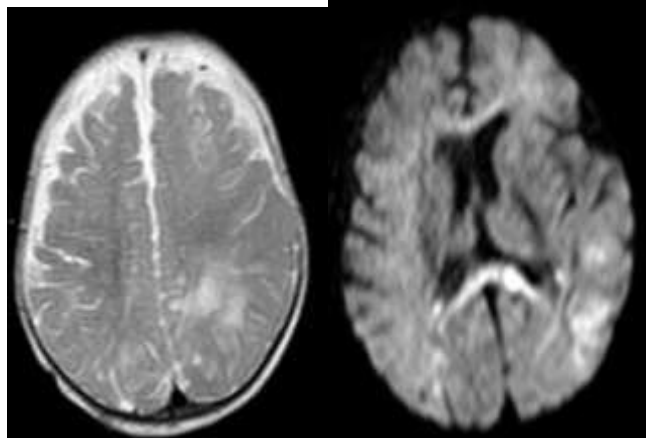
(A) and (B) axial CT images show hypodense areas at left parietal and occipital regions. (C) and (D) axial T2W MRI images, (E) and (F) axial DWIs, (G) and (H) axial and coronal FLAR; showing left lentiform nucleus, parietal and occipital hyper signal intensities, and restricted diffusion. Case 2. Female child 9-months, diagnosed as MIS-C with neurological manifestations, CT and MRI findings suggest acute ischemic infarcts. (A) axial CT images show hypodense areas at both parietal and occipital regions. (B) and (C) axial T2W MRI images, (D) and (E) axial DWIs, (F) and (G) axial FLAR; showing corpus callosum, both parietal and occipital hyper signal intensities and restricted diffusion.
